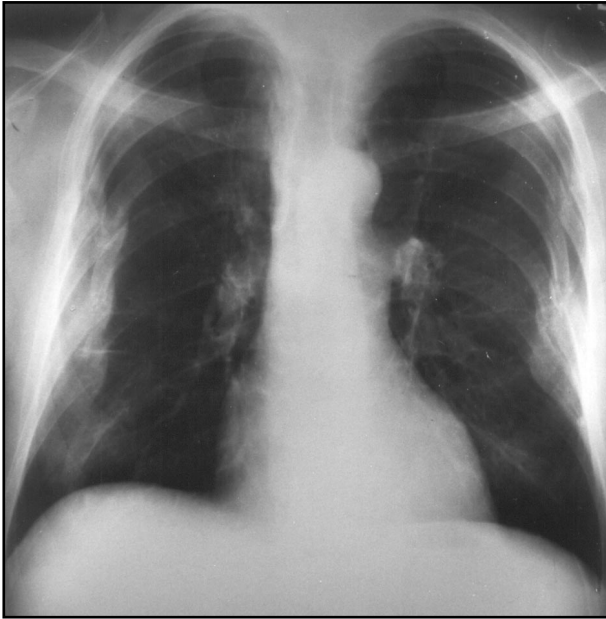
Chest radiographs of a 61-year-old male on hemodialysis for 7 years for chronic renal failure with markedly elevated serum aluminum level.
